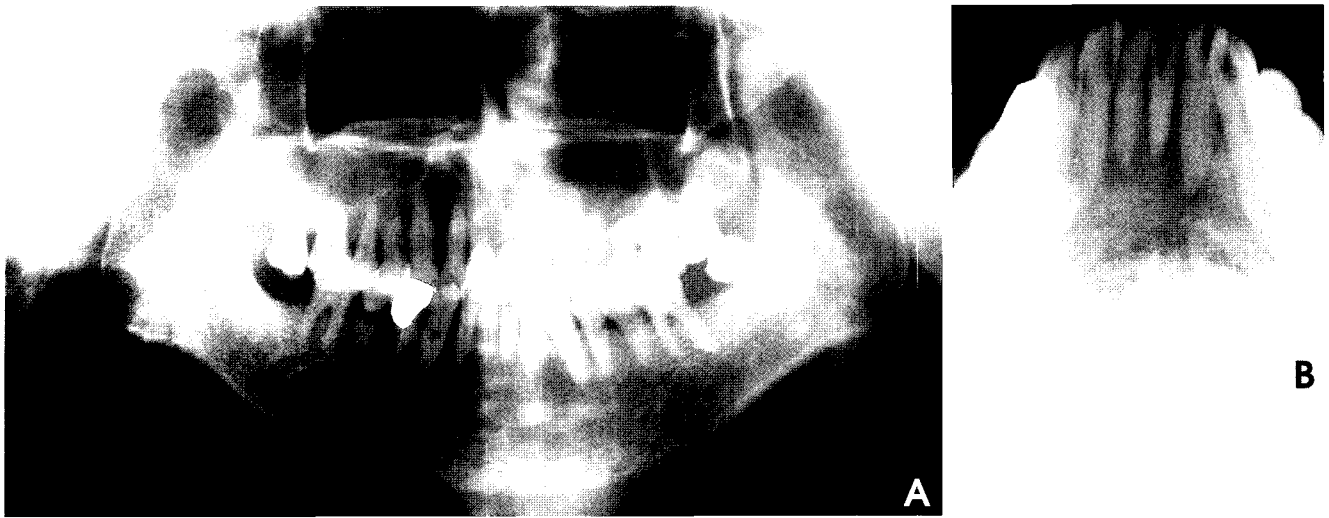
Panoramic (A) and topographic occlusal (B) radiographs showing an ill-defined, radiolucent lesion extending from the right lateral incisor to the left first molar region of the mandible.
